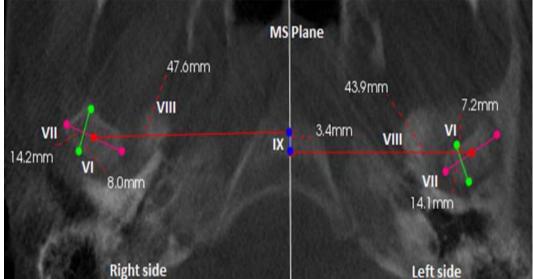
(b):-CBCT Variables and their measurements.
